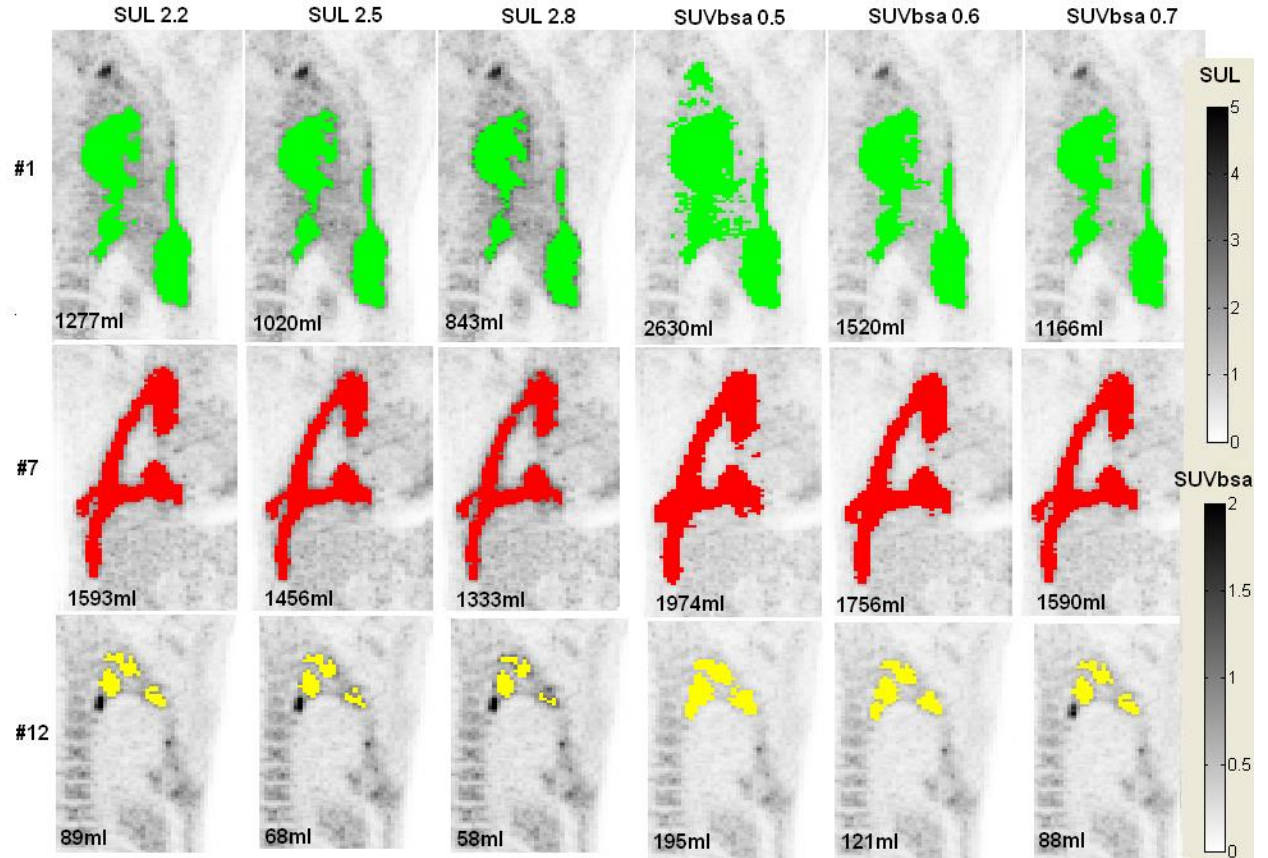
Segmentation using Different Fixed SUL and SUV_{BSA} Thresholds
